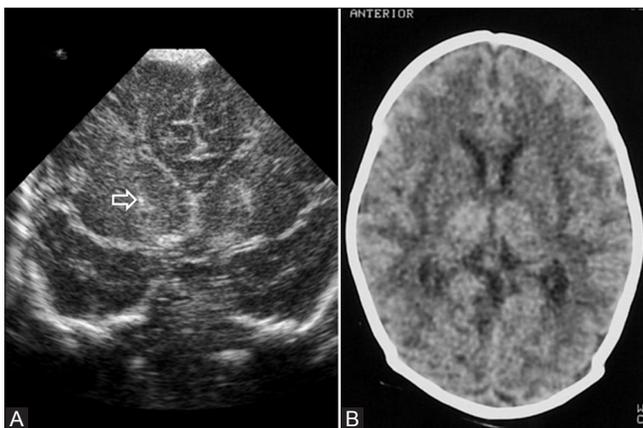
(A, B): Acute ischemic changes demonstrated by coronal USG as the focal hyperechoic (open arrow) changes in the ganglionic areas (A). Corresponding axial non-contrast CT (B) showing the relative decrease in the density of ganglionic areas, a sign of acute ischemia
